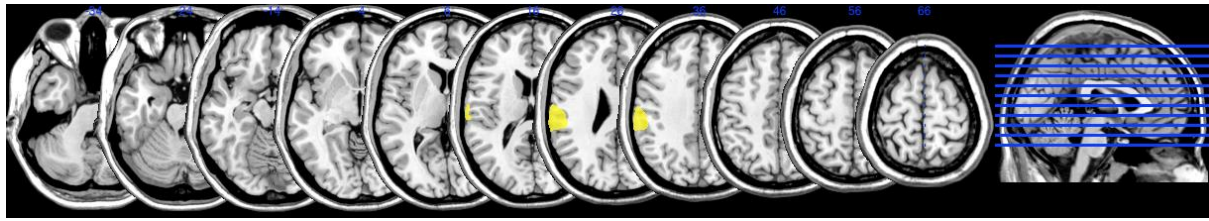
MRI scan of patient CR
